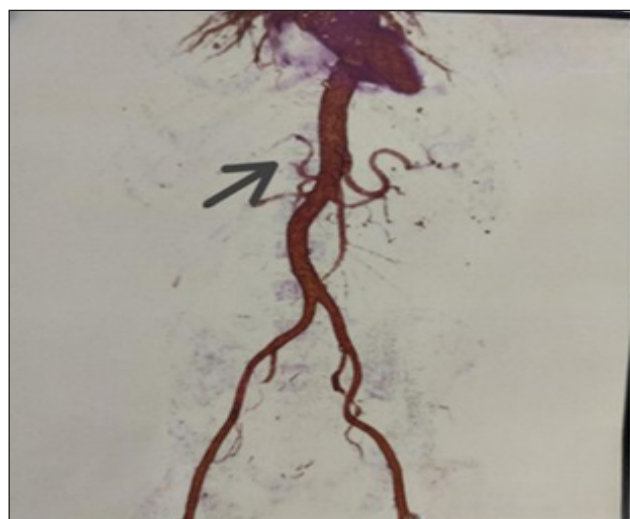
CT arteriography showing right hepatic artery injury with ligation.
